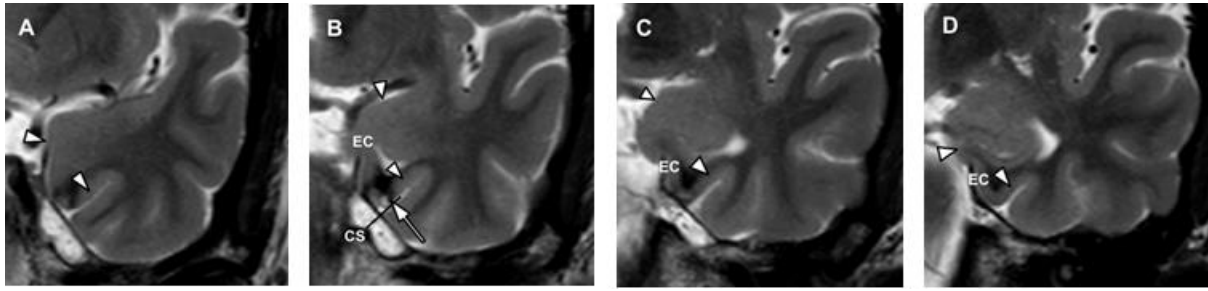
T2-weighted coronal imaging of MRs cavernoma (white arrow, EC = entorhinal cortex; CS = collateral sulcus). Orientation of the coronal images is perpendicular to the longitudinal axis of the hippocampus and slice thickness is 2 mm. Following previous protocol [17], this series of images shows the landmarks used to identify the hippocampal and rhinal cortical areas. It would appear that MR's cavernoma and its surrounding hemosiderin halo (surrounding susceptibility artefact = black) covers the lateral part of the left entorhinal cortex, as in [7].
